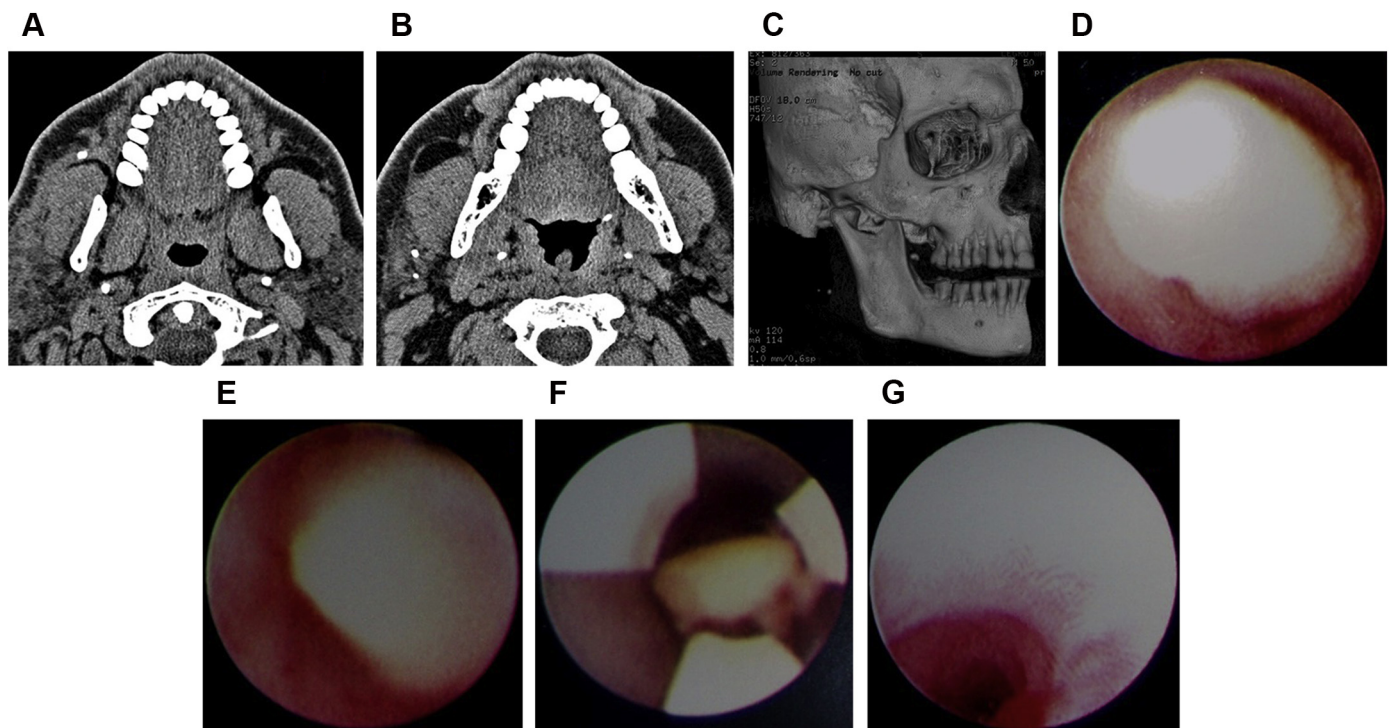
(A, B) Axial; (C) 3D reconstruction CT of right parotid stone; and (D–G) subsequent endoscopic removal.
